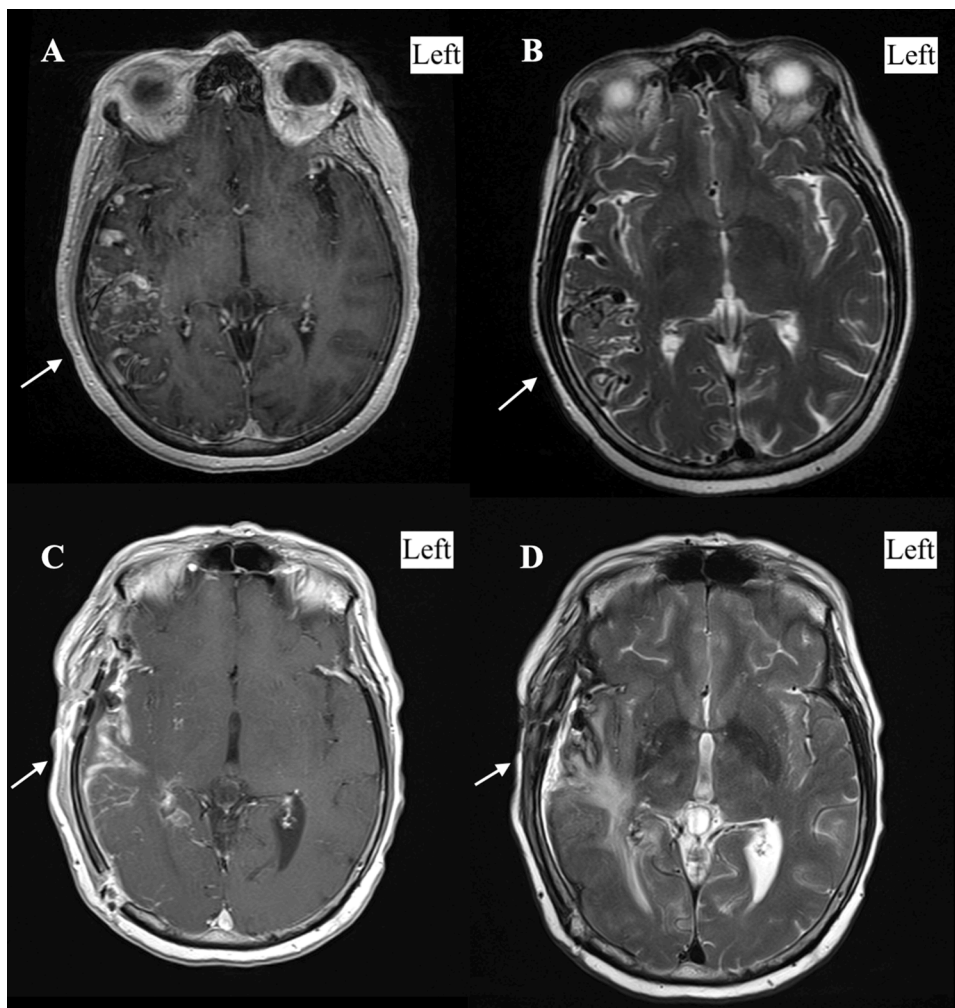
The figure shows the case of a 59-year-old patient with seizure onset. Since about a year before, it was reported by family members the presence of cognitive impairment with difficulty in recognizing people. MRI images (A-B) document the presence of a surgically treated right temporo-parietal artero-venous malformation (AVM) with deep venous drainage (white arrow). Postoperative MRI follow-up (C-D) performed after six months shows the outcome of the removal of the vascular lesion; the patient had complete regression of symptoms within three months.
